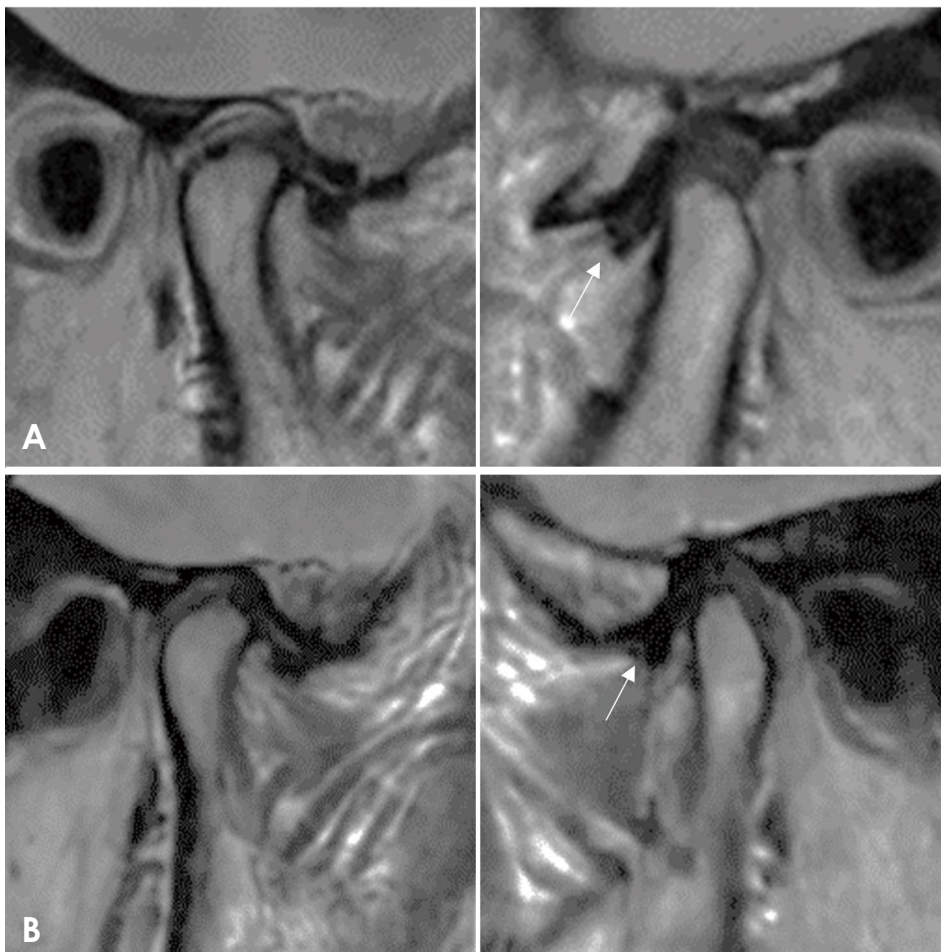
A. Pre-treatment: sagittal magnetic resonance image (MRI) of the right condyle reveals disk displacement in the closed-mouth condition, with the posterior band of the disk positioned anterior to the condyle (white arrow). The disk on the left condyle is in the normal position. B. Post-treatment: sagittal MRI of the right condyle taken 3 months after treatment shows the articular disk has returned to its normal, centric position atop the condyle (white arrow).
